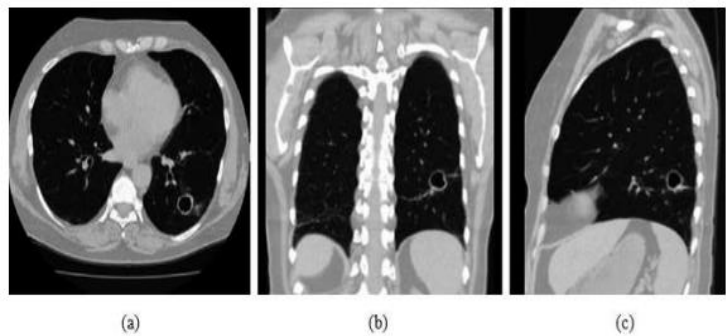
Figure 3shows axial, coronal, and sagittal views of a lung CT picture
